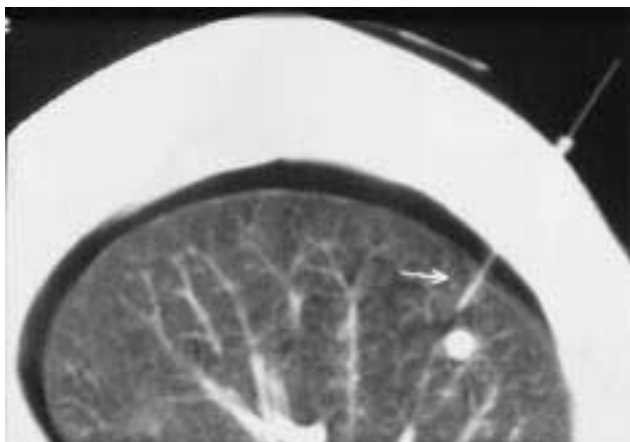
Pulmonary nodule localized with the computed tomography-guided wire technique (the arrow shows the closeness of the hook-wire to the nodule).
